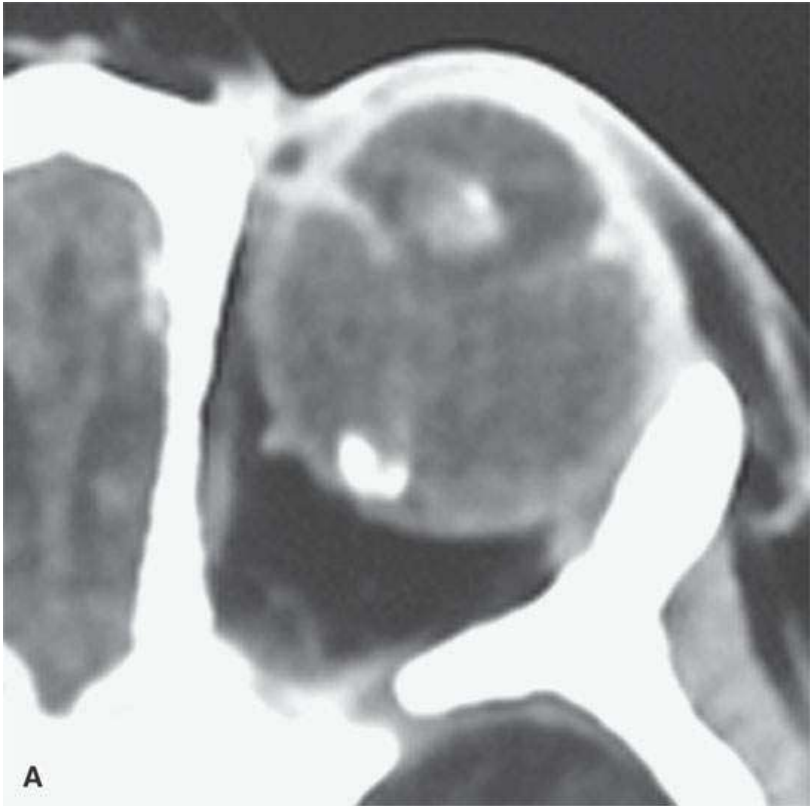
Computed tomography of the hyperdense mucosal changes of tympanosclerosis (*arrows*) that approach and in some areas match the visible density of the ossicles (*arrowhead* in B).
